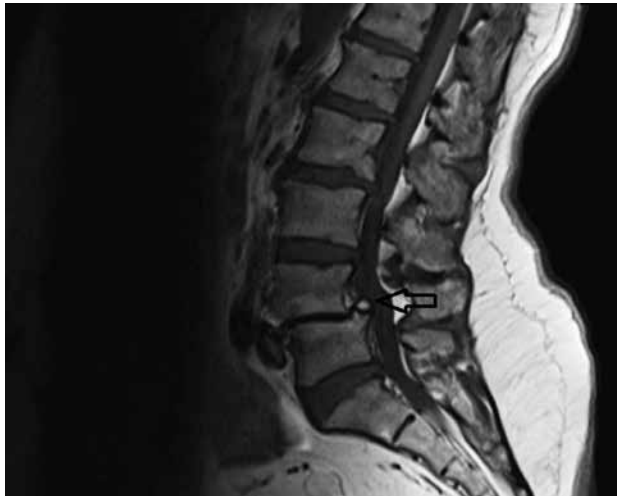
The magnetic resonance imaging of the lumbar spine revealed a large bony fragment over the posteriorsuperior portion of the lumbar vertebral body
